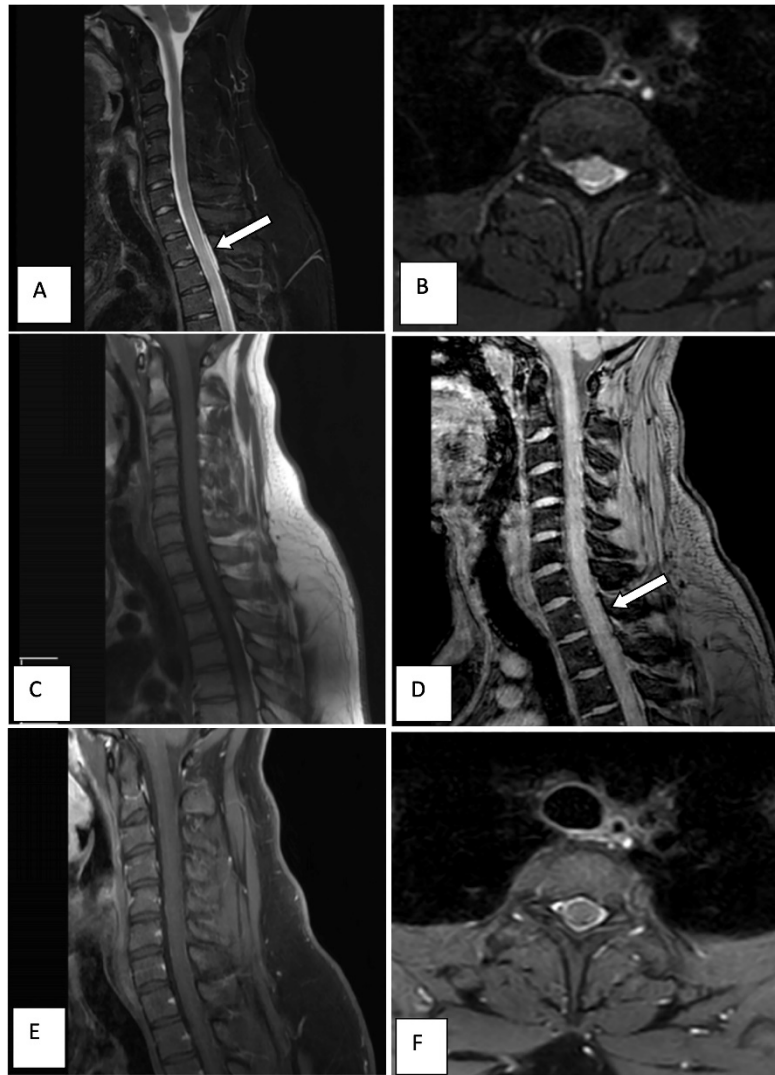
MR imaging repeated after 3 days revealed significant reduction in the size of the previously noted epidural lesion. A thin linear streak of hyperintensity is noted on T2W sagittal image at D2-D3 level (A, white arrow) with no mass effect on the spinal cord (B). No obvious signal abnormality detected on T1W image (C). Thin linear susceptibility signals with negative phase can be seen on SWI sequence at D1-D3 level (D, white arrow). No evidence of any abnormal enhancement noted on post contrast images (E and F).
